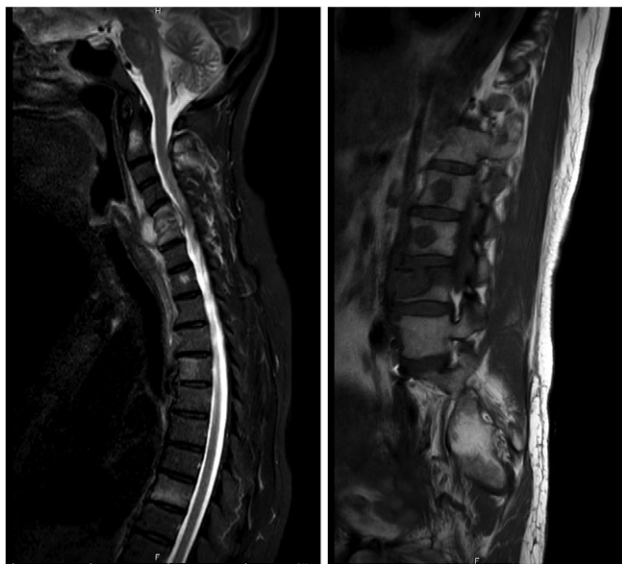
MRI whole spine performed in May 2015 revealed multi-level osteolytic infiltration including impending cord compression at C5/6.
